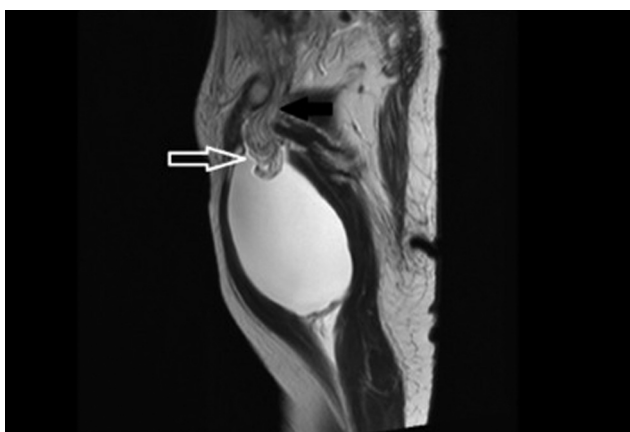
Sagittal T1-weighted MR image: Omental fat (white arrow) is seen in the left obturator canal (black arrow).
